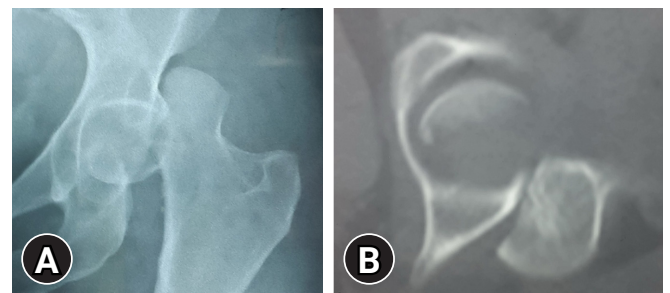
Radiological images. (A) Anteroposterior x-ray of the hip revealing posterior hip dislocation accompanied by Pipkin type II fracture. (B) Axial computed tomography scan showing the posterior hip dislocation and the fractured femoral head fragment, which remained in the acetabulum.
